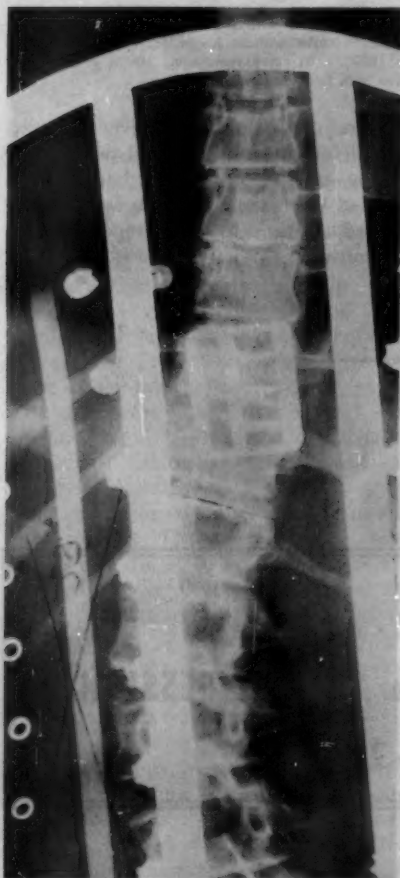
X-ray of spine of patient in figure 4 supported by brace alone.
